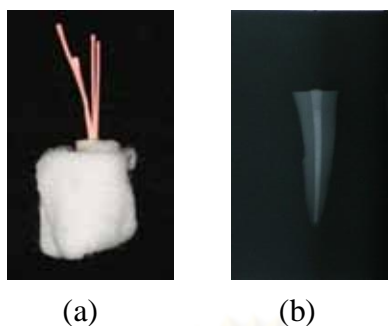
Root canal obturation with a lateral condensation technique (a) and radiograph after root canal treatment (b).
